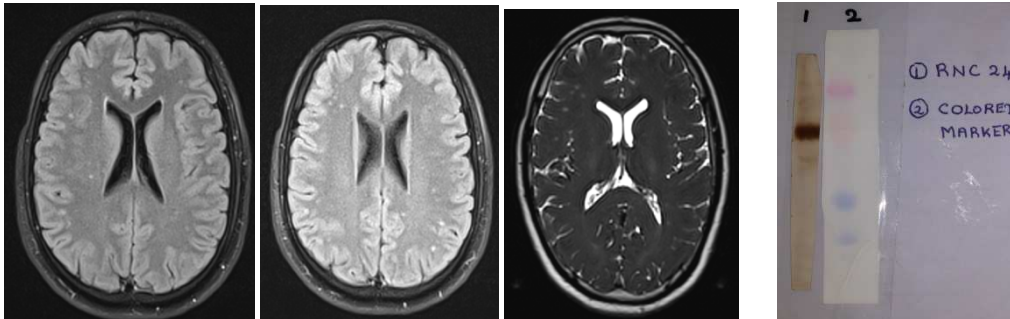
MRI images of brain as shown showing no lesion Figure 11: positive serology
